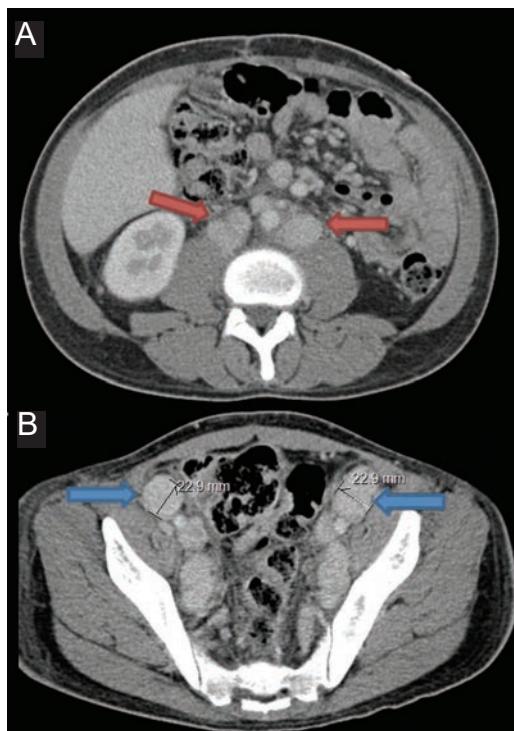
Abdomen/pelvis computed tomography. A) Diffuse abdominopelvic lymphadenopathy (red arrows); B) bilateral inguinal and iliac lymphadenopathy (blue arrows).
